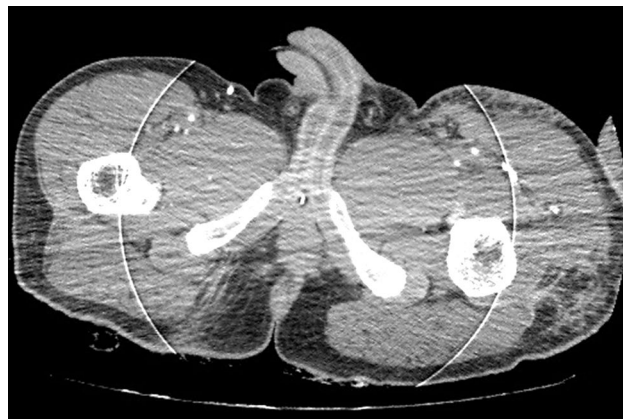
Computed tomography angiography section demonstrating no bleeding after the second operation.
